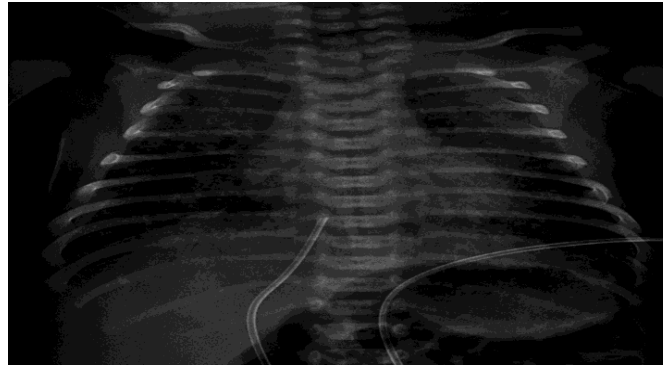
Chest radiography of a full-term infant with meconium aspiration ⁽²⁷⁾.
